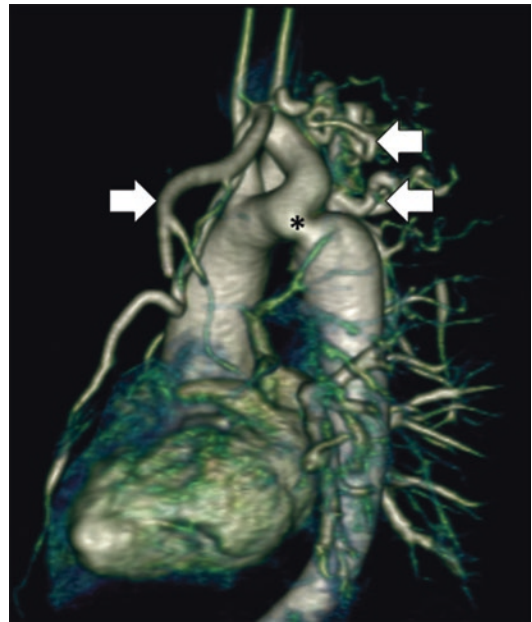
Underestimation of coarctation gradient due to collateral flow. In cases of significant coarctation, it is possible for echocardiography to underestimate the severity of coarctation if run-off down large collateral vessels (arrows) means that the volume of flow across the coarct segment (asterisk), and therefore its velocity, is reduced. One way of recognising this is by using phase-contrast imaging to measure the flow in the aorta at two levels—firstly, just beyond the coarct and, secondly, at the level of the diaphragm. A significant increase in measured flow between these two points implies that there is significant collateral return to the descending aorta
